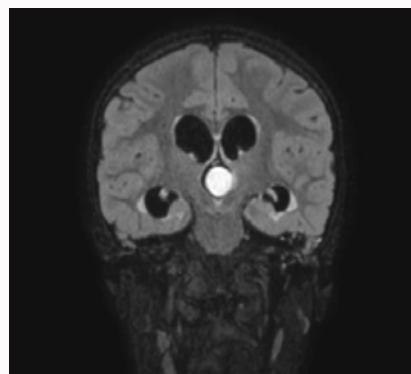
Coronal T2-FLAIR-weighted image showing pineal lesion in the upper part of the aqueduct with resultant moderate to severe acute hydrocephalus, and secondary mild to moderate trans-ependymal CSF seepage.
